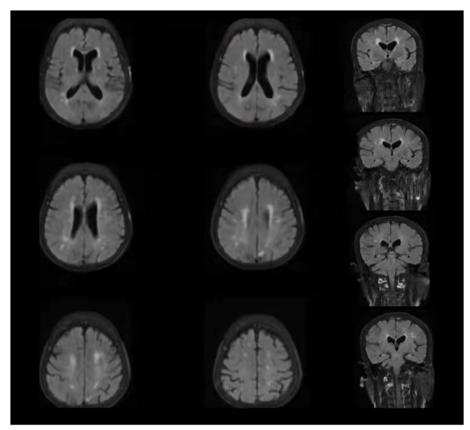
The patient's MRI results
